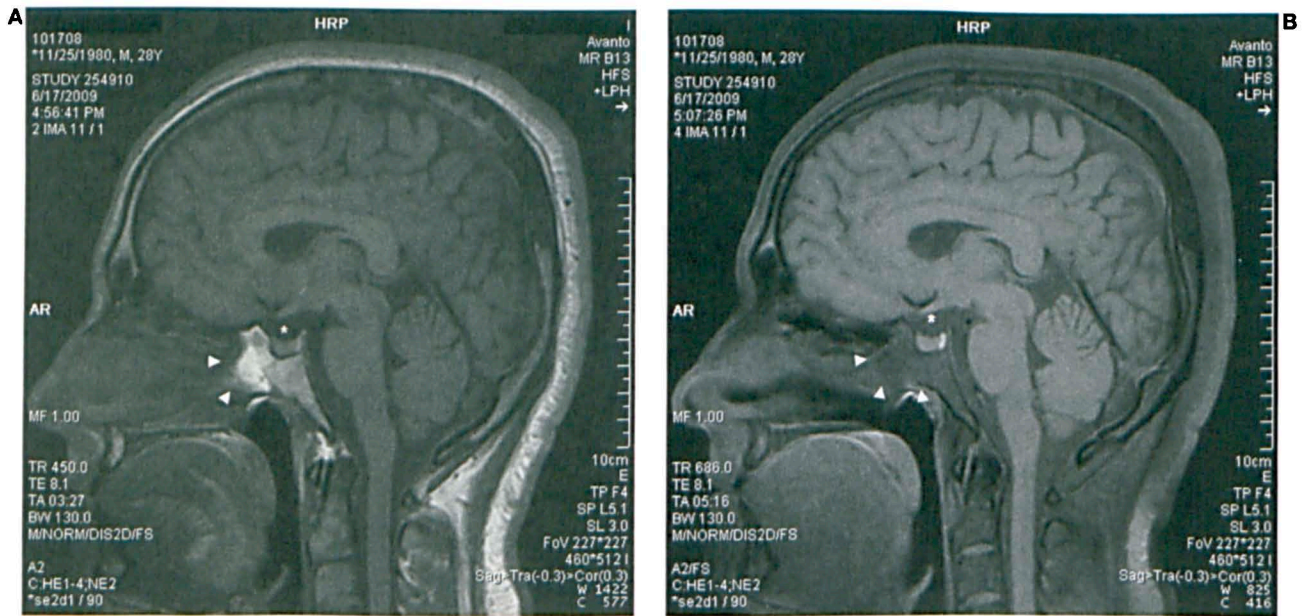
A: The area of high signal intensity (arrowheads) is seen on T1-weighted MRI. B: Fat-saturated MRI shows the fatty-appearing area (arrowheads) that indicates the presence of yellow marrow instead of air in the corpus sphenoidale. The star symbol represents the pituitary gland.
